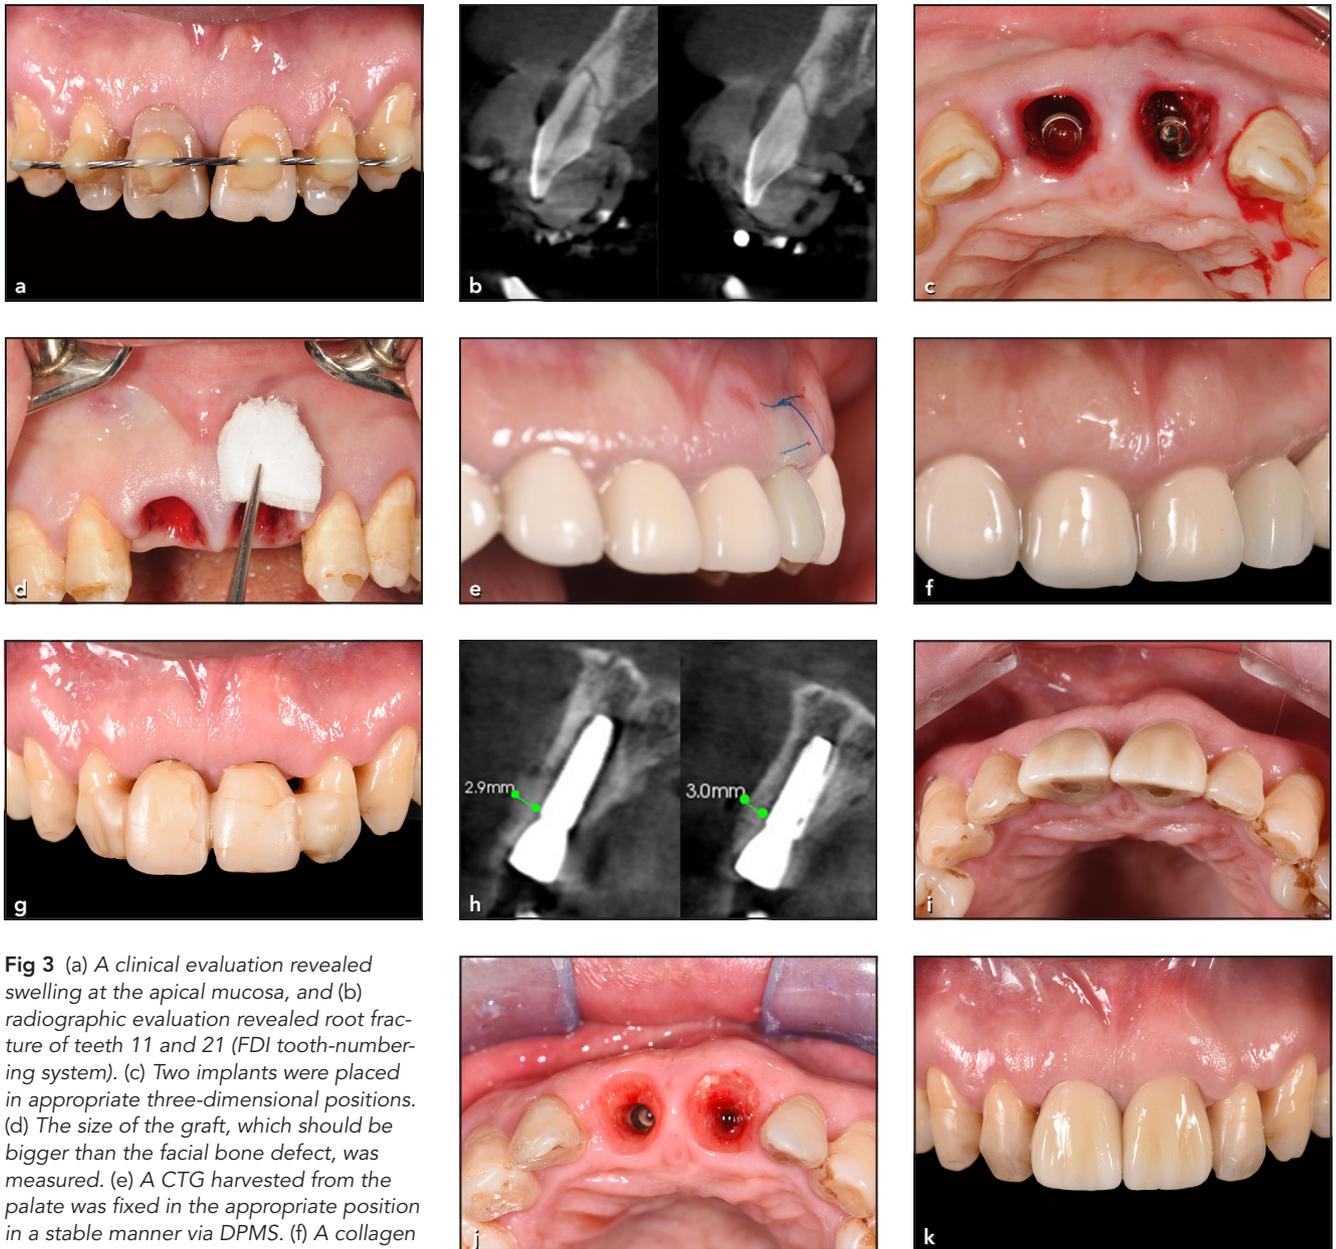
(a) A clinical evaluation revealed swelling at the apical mucosa, and (b) radiographic evaluation revealed root fracture of teeth 11 and 21 (FDI tooth-numbering system). (c) Two implants were placed in appropriate three-dimensional positions. (d) The size of the graft, which should be bigger than the facial bone defect, was measured. (e) A CTG harvested from the palate was fixed in the appropriate position in a stable manner via DPMS. (f) A collagen membrane and bone graft were used to regenerate the buccal wall. (g) Provisional fixed partial dentures were used to support the soft tissue. (h) CBCT scans showed appropriate implant positioning. (i) Provisional crowns were placed 3 months later [Au: 3 months after the provisional restoration, or 3 months after surgery?]. (j) The buccal contour at site 21 was better than the initial situation. (k) Clinical view after treatment completion.
